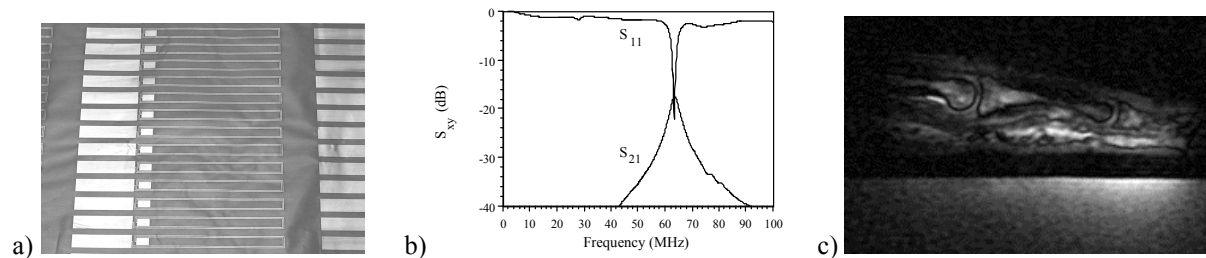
a) Thin-film RF detectors; b) frequency response of detector system; c) ¹H MR image of human finger obtained at 1.5 T.
